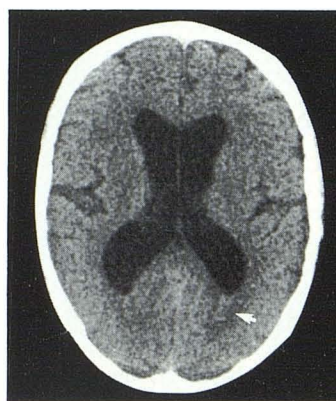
A, Normal baseline axial CT scan at level of lateral ventricles in workup of chronic dementia. B, Unenhanced scan 2 years later for meningitis. Occipital horns of lateral ventricles are normal. C, After contrast administration. Linear enhancement of ependymal margins of occipital horns of lateral ventricles. D, Unenhanced scan 1½ months later for persistent confusion and agitation. Soft-tissue sludge in occipital horns of left (arrow) and right lateral ventricles is nearly isodense with surrounding brain parenchyma and represents necrotic cellular debris. (Identical findings were present on unenhanced scan 5 days before.) E, Enhanced scan immediately after D. Opacification of occipital horns of lateral ventricles by contrast extravasated into ventricular system. Meniscus (arrow) is formed by posterior layering of contrast. (Identical findings were present on enhanced scan 7 days before.)
